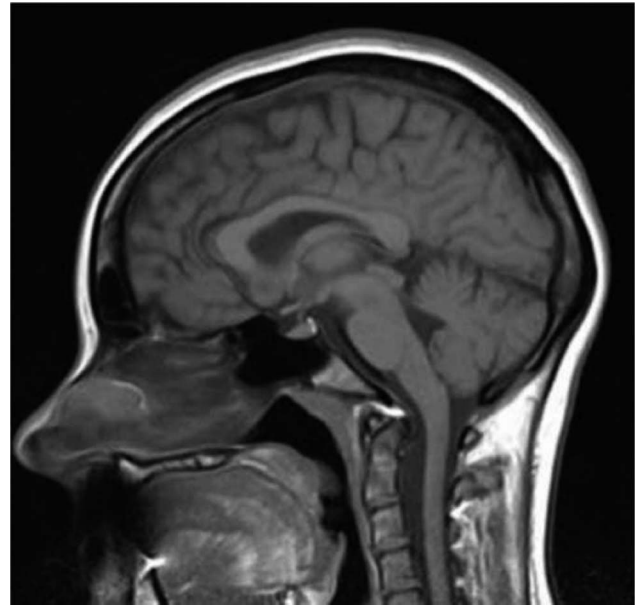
MRI study of the brain showing cerebral hemispheres on sagittal view.
